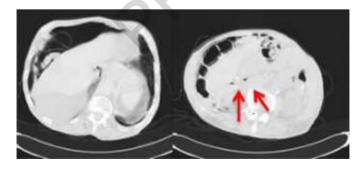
Preoperative CT scan (red arrows on intraparietal bubbles of the 1st bowel loop).
